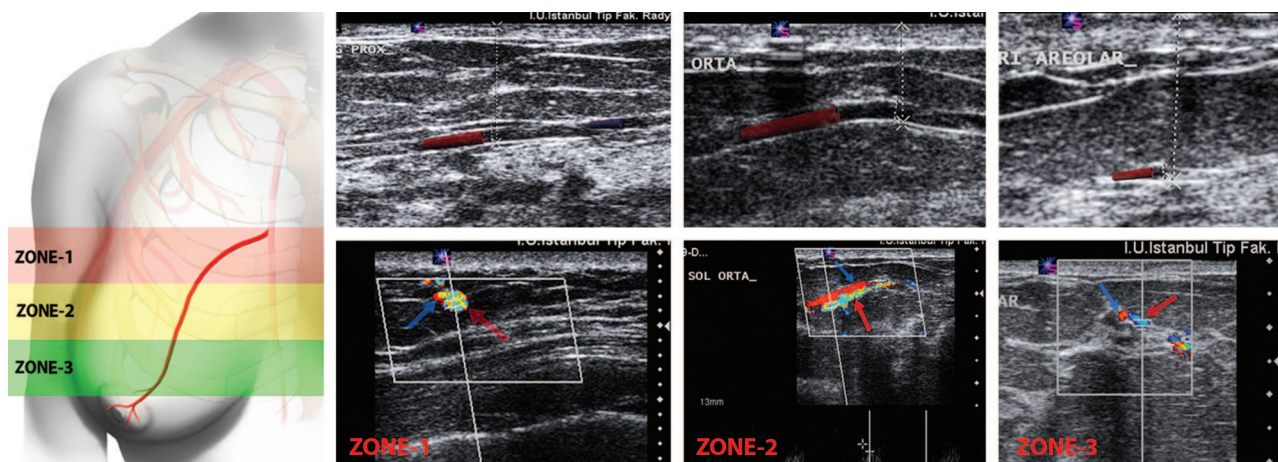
Doppler images of the main perforators. For the purpose of documentation, measurements were taken in three different zones. The dotted lines designate the distance of the artery to the surface in all zones. Arteries are highlighted with red, whereas veins are highlighted with blue (above). Red arrows indicate the artery, whereas the blue arrows designate the veins on spectral images (below).
